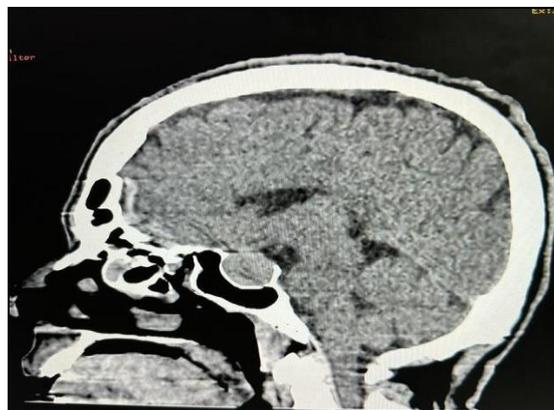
MRI of Brain showing adenoma of pituitary gland with compression of pituitary stalk.
